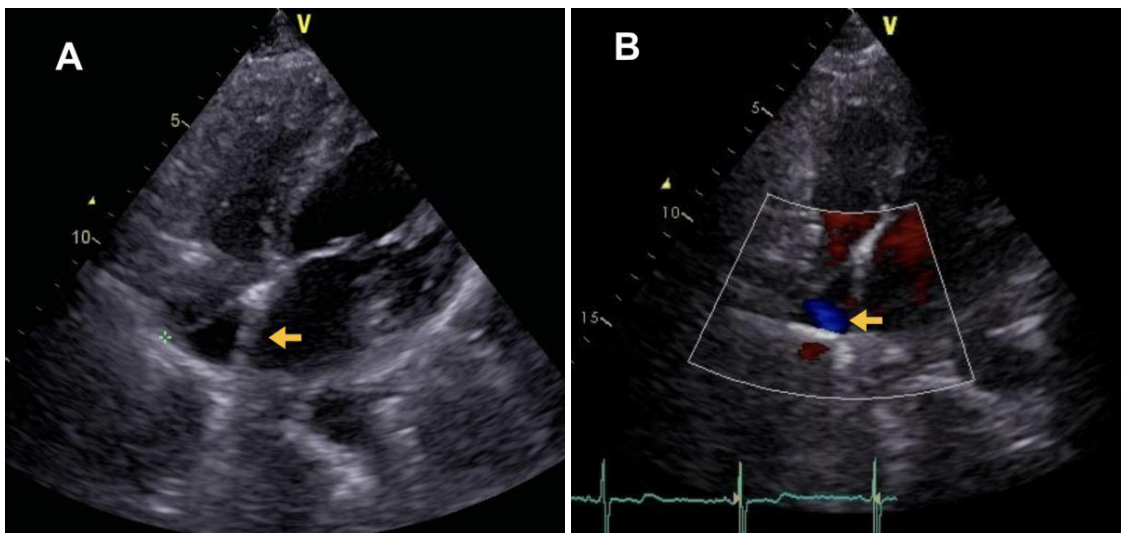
Color ultrasound examination of the heart in the patient. (A) The orange arrows indicate the presence of a longitudinal septum in the middle of the right atrium. (B) The orange arrows indicate red blood flow in the upper part of the right atrium and blue blood flow in the lower part, unable to pass through the septum in the middle of the right atrium.
